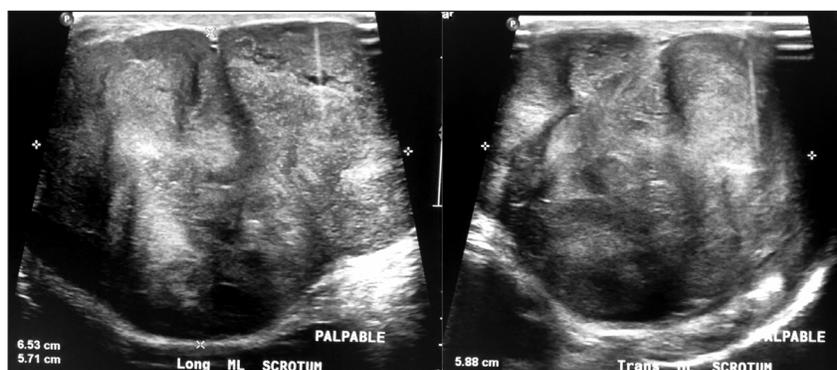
Testicular Ultrasound. Imaging of the right testicle demonstrates total replacement of normal testicular parenchyma by a solid, inhomogeneous mass.
